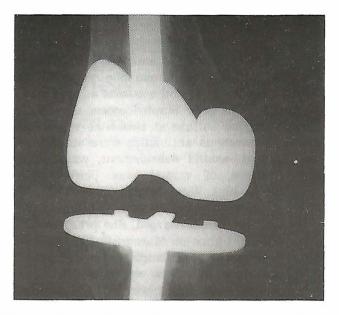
X-rays of knee AP view after removal of bone cement block and revision total knee arthroplasty.
